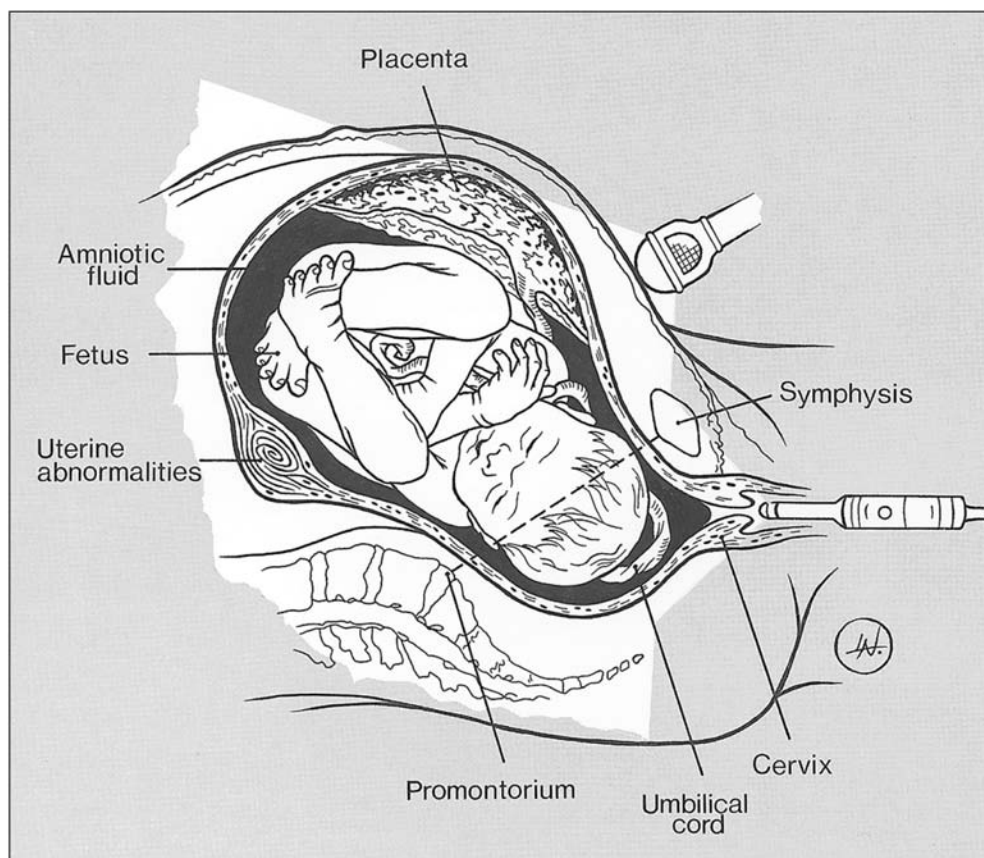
Potential use of intrapartum ultrasound.
